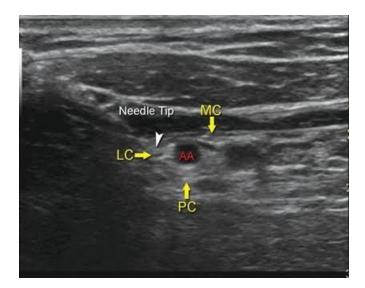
Group 2 ultrasound view of brachial plexus. LC-Lateral cord; PC-Posterior cord; MC-Medial cord; AA-Axillary artery; Note the Medial cord lying between Axillary artery and vein.
